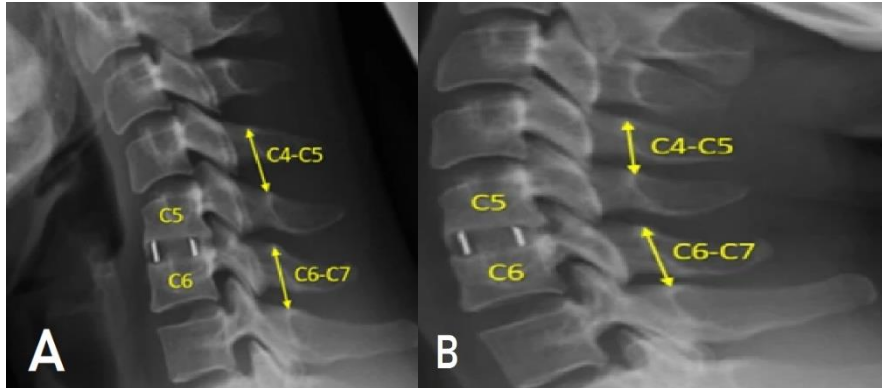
(A) Flexion x-ray, (B) Extension x-ray
